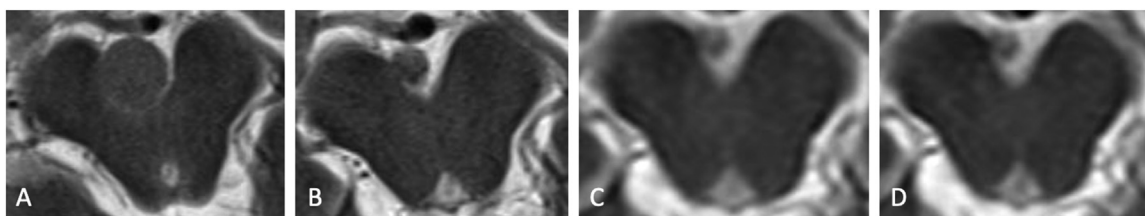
Evolution of the prepontine lesion shown on magnetic resonance imaging. T2-imaging studies: (A) 09.11.2015, (B) 13.03.2016, (C) 30.03.2017, (D) 15.02.2018.
